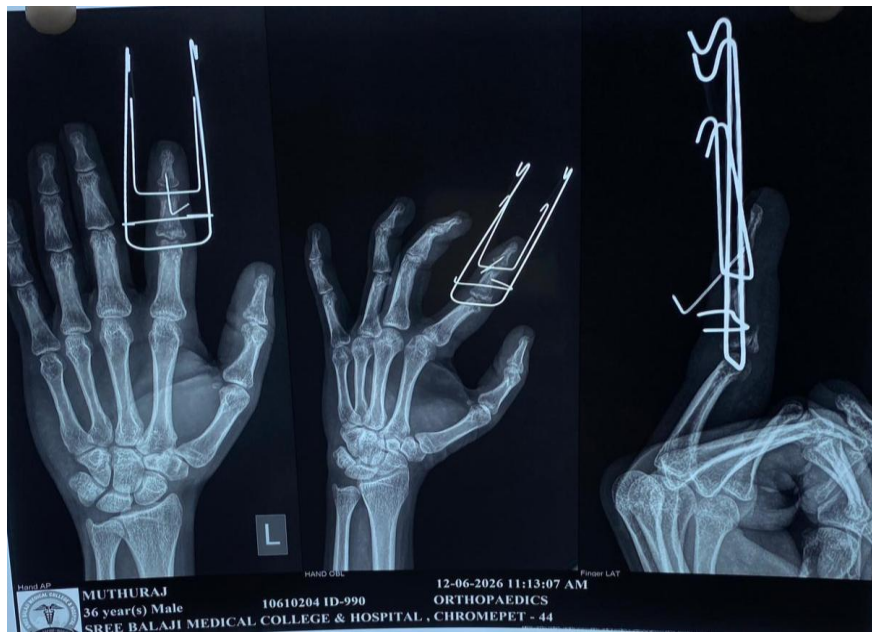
Post-operative follow-up at one month x-ray hand ap and oblique view and index finger demonstrating the Suzuki dynamic external fixation frame with maintained reduction of the index-finger PIP fracture-dislocation.
